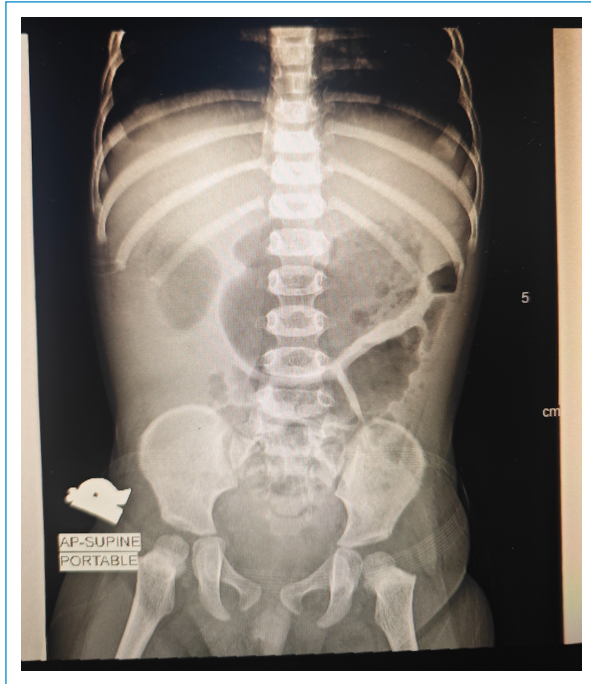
Abdominal radiograph at 16 months of age.
